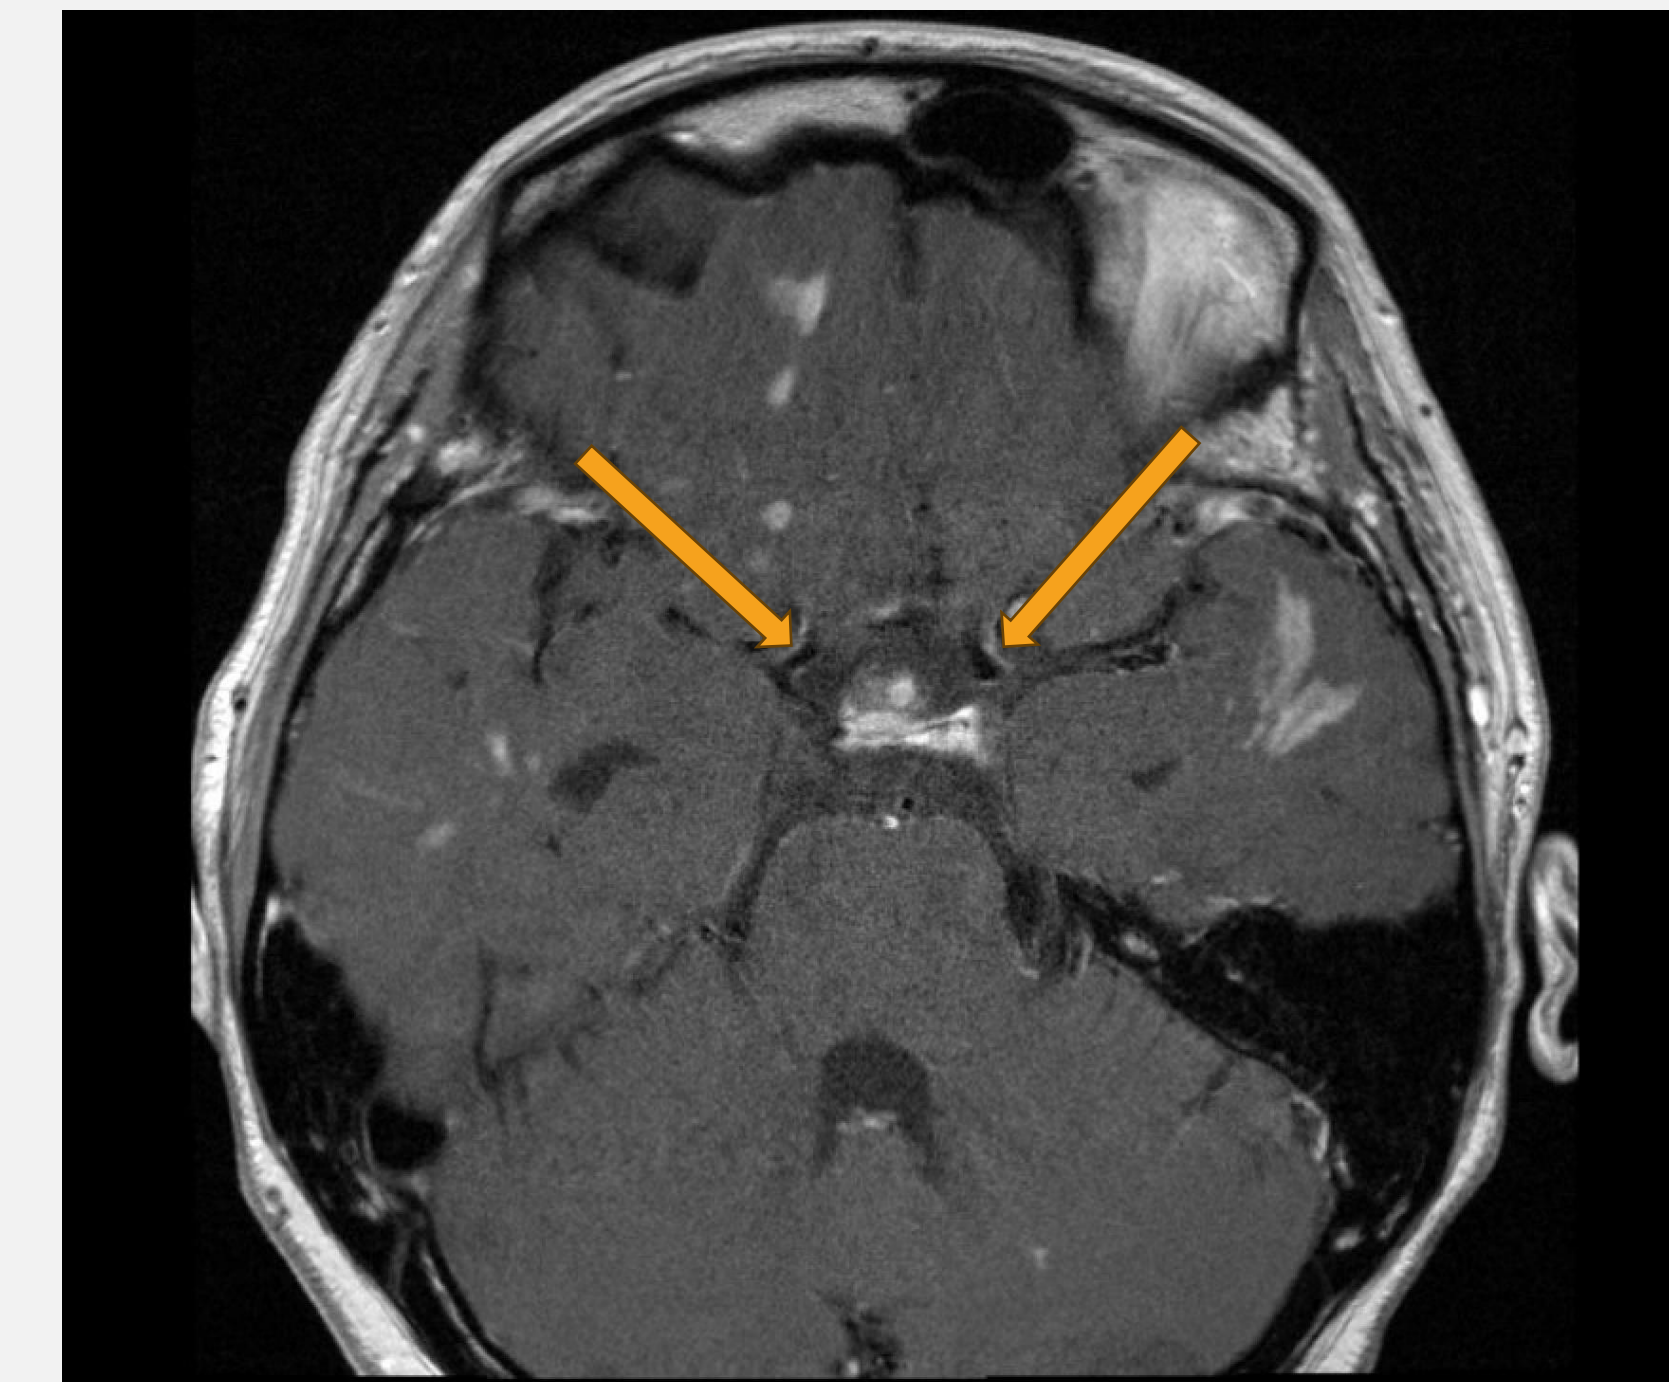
MRI Vessel Wall Imaging demonstrating evidence of vasculitis
